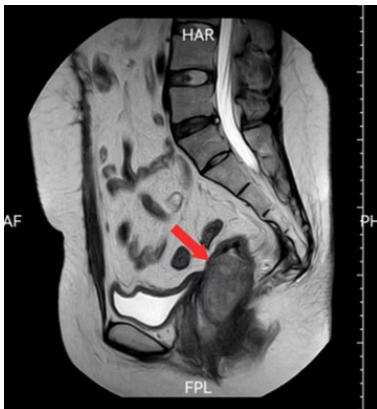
Pelvic magnetic resonance imaging revealed pelvic postoperative changes, soft tissue mass around the rectum, about 4.9cm \times 3.3cm, the DWIBS signal is intensified, suggesting tumor recurrence.
